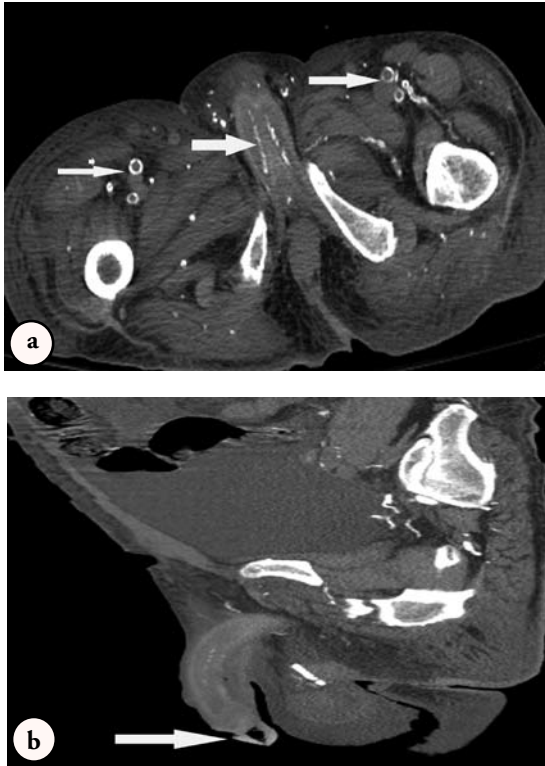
Computed tomography scan of pelvis and upper thighs axial section a) and sagittal reconstruction b) shows diffuse and extensive calcification of the walls of small and medium-sized arteries including the iliac, femoral, pudendal, penile, dorsal penile and cavernosal arteries with almost complete obliteration of the lumen of small arteries. There is air in glans penis representing gangrenous changes on sagittal reconstruction.
